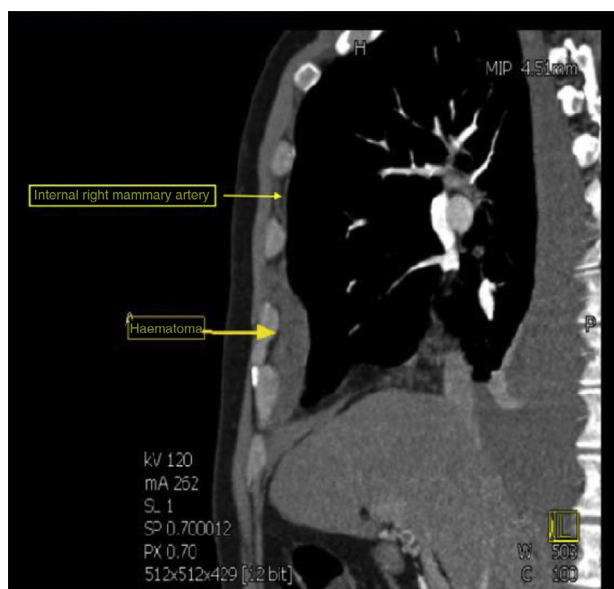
CT image of the thorax, sagittal view. The internal mammary artery and the haematoma that originates from its rupture can be observed.
